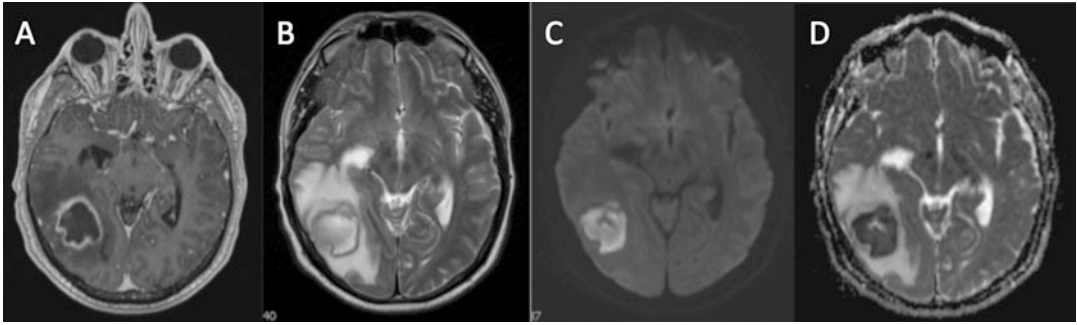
Tumor mimic: bacterial abscess: T1w + Gad (a), T2w (b) and diffusion-weighted images (b1000 DWI (c), ADC map (d)) sequences of a right temporal bacterial
